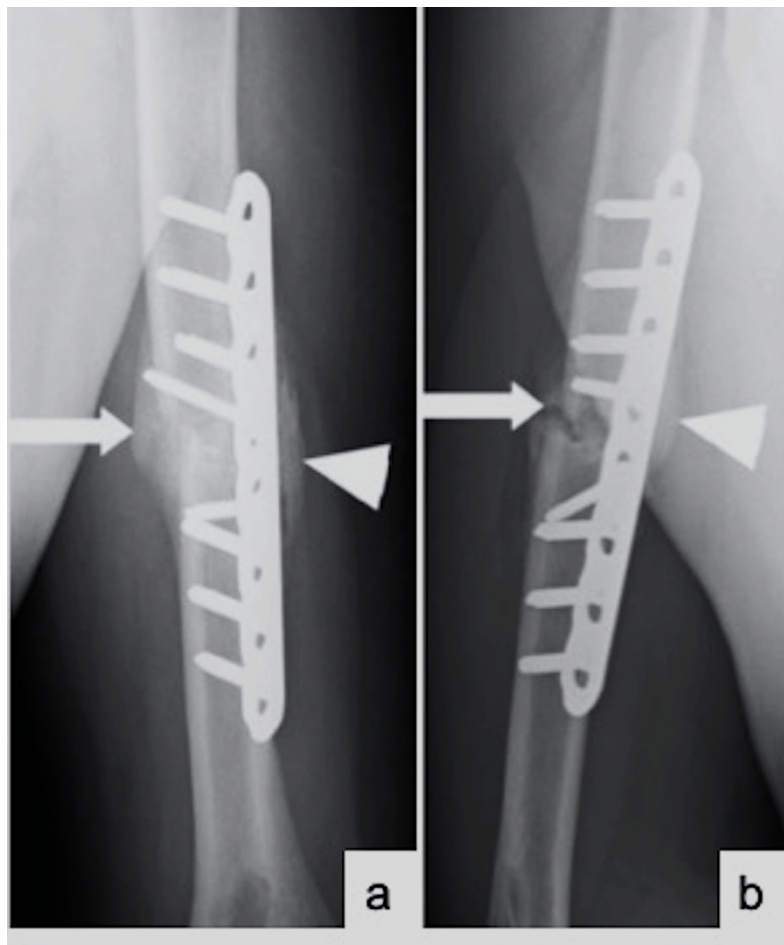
(a) Antero-posterior and (b) lateral radiographs of an arm with a plated humeral shaft fracture. The medial and posterior cortical segments (arrows in a and b) but not the lateral and anterior cortical segments (arrowheads in a and b) of the fracture were assessable. Cortical scores for the medial and posterior cortices were 3 (bridging callus) and 2 (non-bridging callus) respectively. The RUS value was not calculated because of the availability of two out of four cortical scores.
